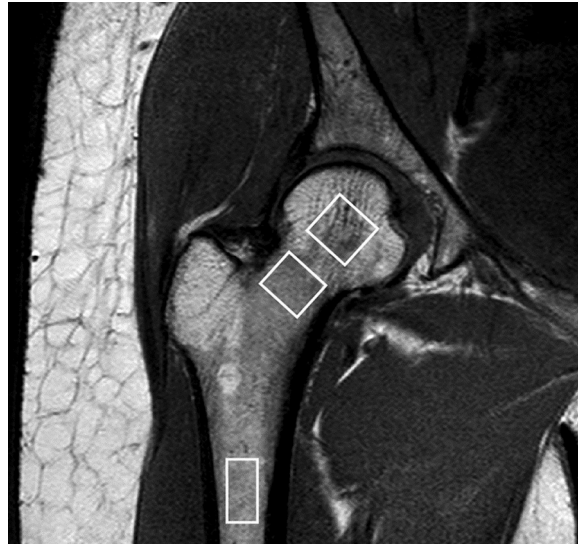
Dynamic contrast-enhanced MRI. Coronal oblique T1-weighted image of proximal femur showing regions of interest used to measure marrow perfusion in the femoral head, neck, and shaft.
